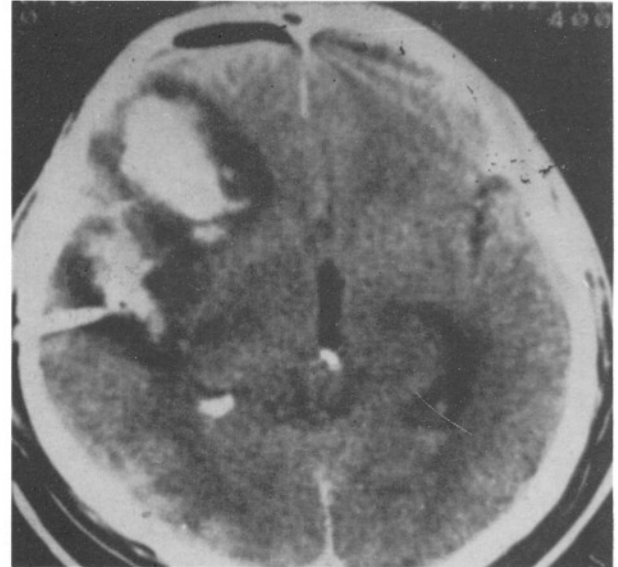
Post-operative CT, twelve hours after the operation, showing the catheter in the haematoma
